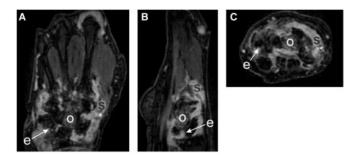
T1-weighted post-contrast fat-suppressed images through the wrist and MCP joints of a patient with long-standing, active RA. (A) coronal, (B) sagittal and (C) axial sections showing examples of synovitis (s), erosion (e) and bone marrow oedema (o). Images acquired using 3D fat-suppressed VIBE sequence at 3T (TR = 8 ms, TE = 4 ms, flip-angle =  $30^{\circ}$ , 0.5 mm isotropic resolution).
